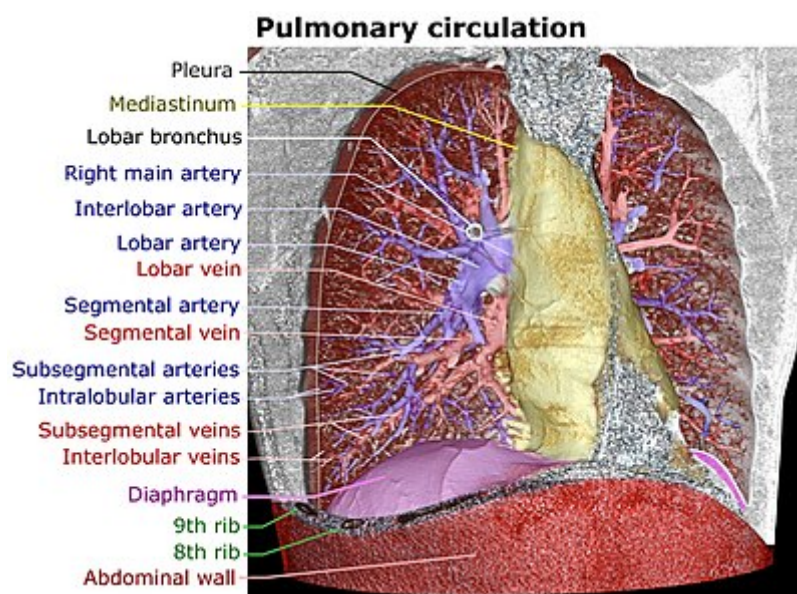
3D rendering of a high resolution computed tomography of the thorax. The anterior thoracic wall, the airways and the pulmonary vessels anterior to the root of the lung have been digitally removed in order to visualize the different levels of the pulmonary circulation (*Drake et al., 2009*).
